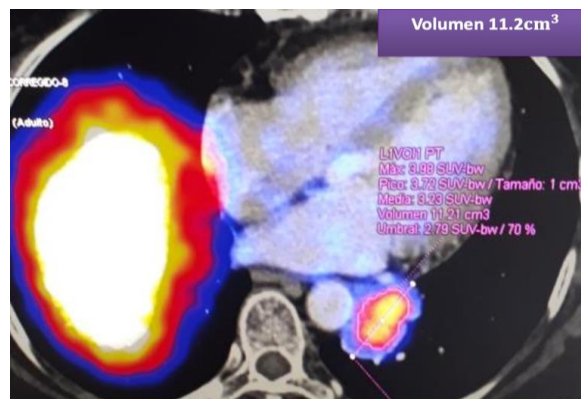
PET/CT Gallium 68 DOTA TOC 2015 left posterobasal lung tumor 46x29x37 mm, with SUVmax 3.9 in contact with the aortic wall and pericardium
